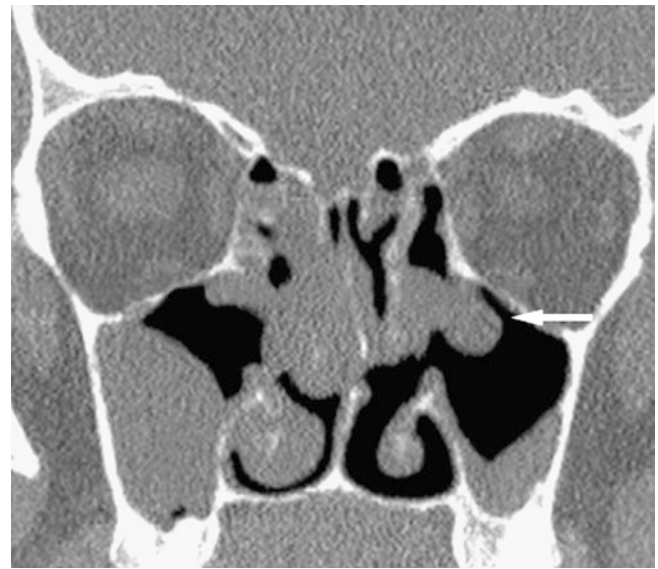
Antrochoanal polyp; 12-year-old male with history of sinusitis and nasopharyngeal mass. (A) Axial CT image shows left maxillary sinus thickening (*asterisk*) with extension of soft-tissue mass into the posterior nasal cavity down to the nasopharynx (*asterisk*), via the ethmoidal infundibulum. No bone destruction. (B) Axial CT image
